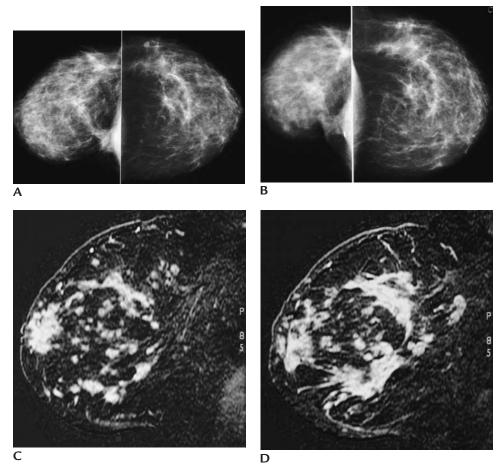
Recurrence, diffuse. (A) Craniocaudal views. Diffuse changes post lumpectomy and radiation therapy, right breast. A mass with indistinct margins is seen posteromedially abutting the right pectoral muscle corresponding to fat necrosis at the lumpectomy site. Increased density of the parenchyma and marked prominence of the trabecular markings reflect radiation therapy effect. (B) Follow up mammogram. The size of the right breast is decreased and the density is increased even more. (C) and (D) Magnetic resonance imaging, subtraction sagittal images, right breast at different table top positions. Multiple enhancing masses are present diffusely involving the breast.
